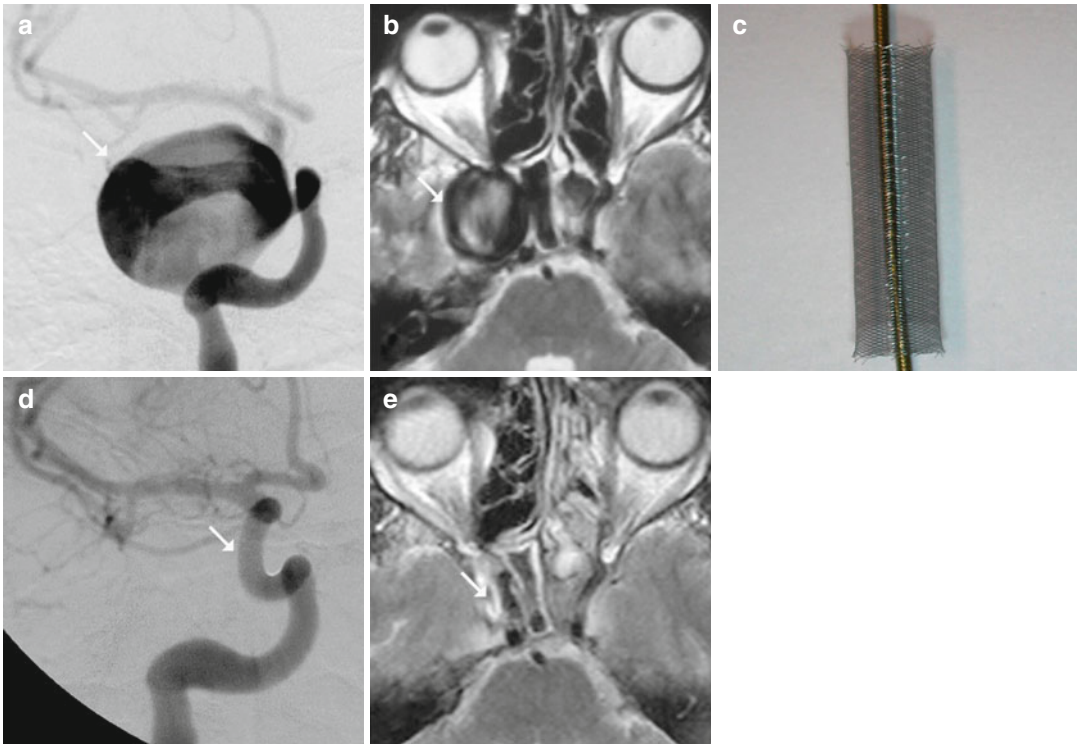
Intracavernous giant aneurysm of the Internal Carotid Artery (ICA) and its neurointerventional treatment with flow diversion. (a) DSA, right ICA contrast angiography, image in oblique PA direction. The giant aneurysm is indicated by an *arrow*. (b) Axial T2-weighted spin echo MR image. On the right side the lateral wall of the cavernous sinus is laterally bent, the giant aneurysm within it can be seen as a flow void signal (*arrow*). (c)
